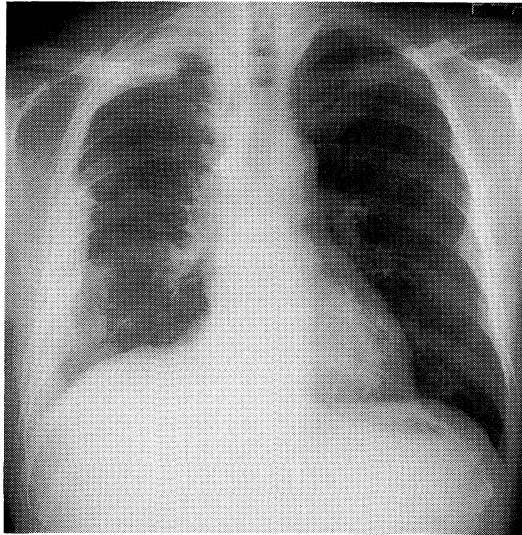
Chest X-ray on admission showing diffuse pleural thickening on the right.
